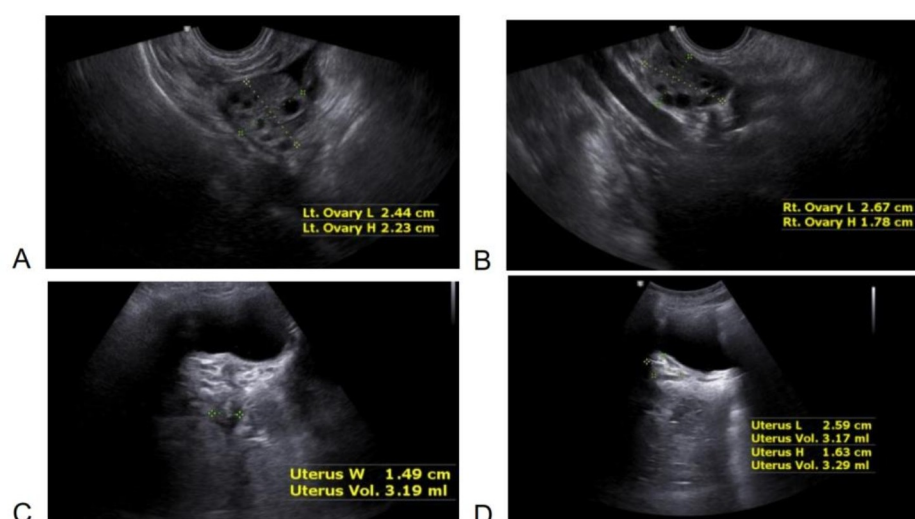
Transrectal ultrasound images. A: Left ovary. B: Right ovary. C & D: Uterus.
